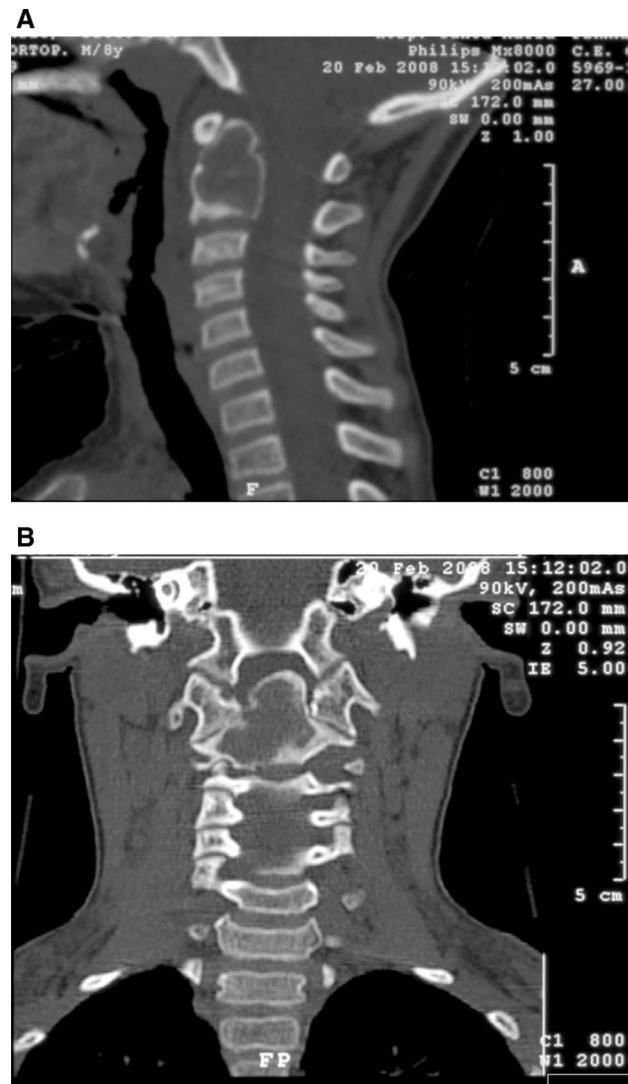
Pathologic type III odontoid fracture fracture—CT scan sagittal view
